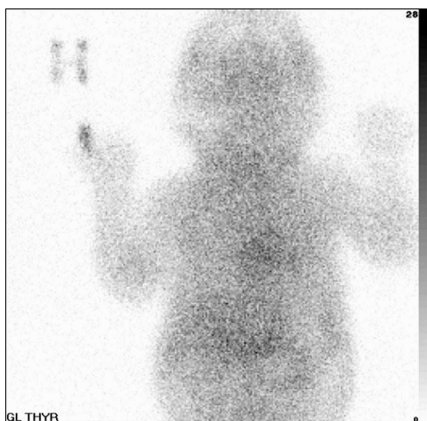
$^{99m}\text{Tc}$  pertechnetate thyroid scintigraphy in a 7-year-old boy with congenital hypothyroidism and a palpable diffuse goiter (scan performed without preceding thyroxine withdrawal). Diffuse uptake in an enlarged gland can be seen. Two weeks later an additional perchlorate discharge test was performed: injection of 10 MBq  $^{123}\text{I}$  showed diffuse uptake after 60 min at which time sodium perchlorate (20 mg/kg) was administered. Uptake measurements every 15 min the following hour showed increased discharge reaching a level of 43% of the maximum uptake after 30–45 min. Results are compatible with a partial thyroid peroxidase defect explaining the goiter and concomitant hypothyroidism.
